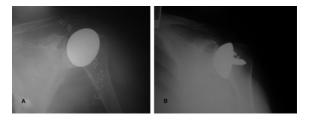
(A, B) The postoperative x-rays of the humeral head surface arthroplasty
